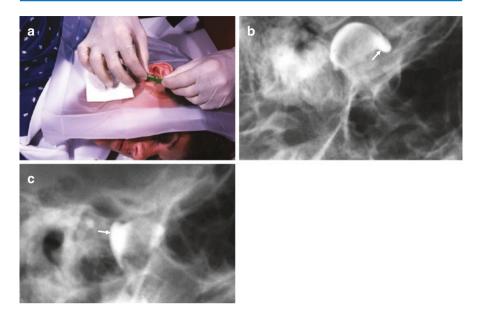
(a) Joint puncture for contrast injection into the lower joint space, using a 23-gauge butterfly needle. The direction of the needle is guided by fluoroscopic guidance of the location of the osseous anatomy versus the needle direction. The needle is actually advanced into the joint space by feel, rather than direct observation. (b) Closed jaw, transcranial spot radiograph with contrast in the normal lower joint space. The anterior recess is well shown (arrow). (c) Opened jaw, normal lower joint space arthrogram. The disc position and function are identified indirectly by the configuration and movement of the contrast material into the posterior recess (arrow) on the openmouth image
